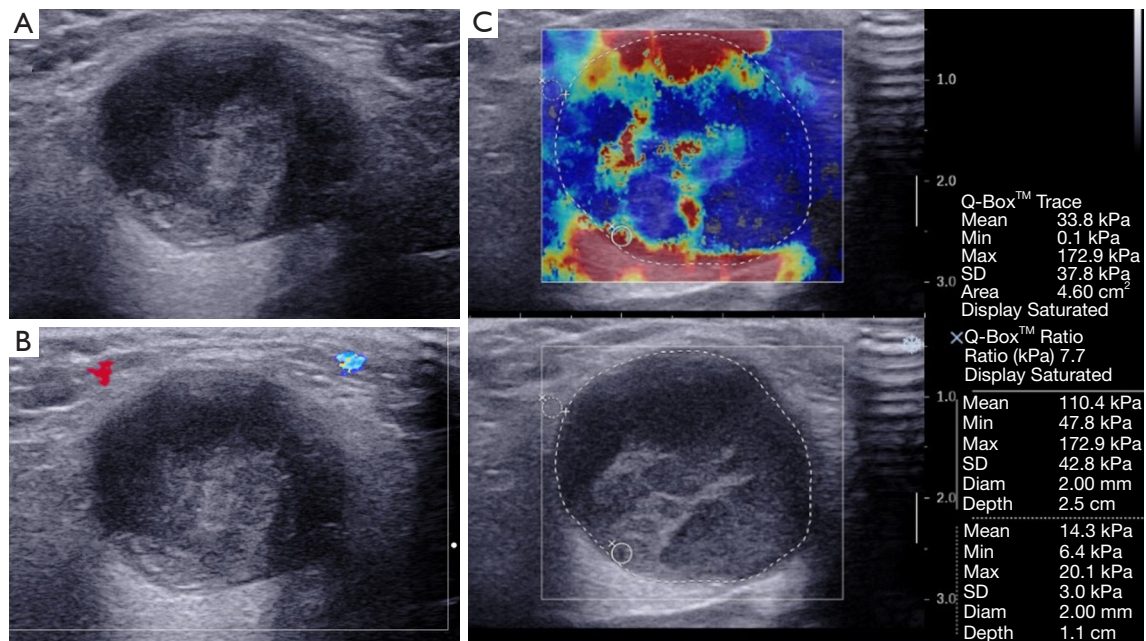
PA in the right parotid gland, F, 44Y. (A) B-mode ultrasound (B) CDFI: Grade 2 (C) SWE: Emax =34.1 KPa, Emean =7.1 KPa, SD =5.6 KPa, Eratio =2.1. Elastography showed stiff ring sign. PA, pleomorphic adenoma; F, female; Y, years; Emax, maximum Young’s modulus; Emean, mean Young’s modulus; SD, Young’s modulus standard deviation; Eratio, Young’s modulus ratio of mass-to-surrounding normal glands; Area, maximum cross-sectional area; Diam, size of Q-box; Depth, depth of mass; SWE, shear wave elastography.
